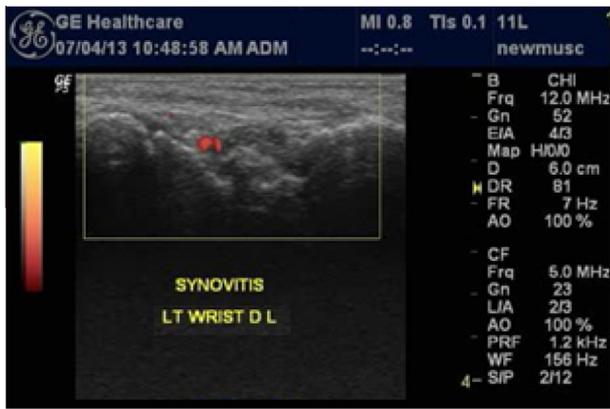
Ultrasonographic image of the left wrist showing synovitis with grade 1 PD signal.
